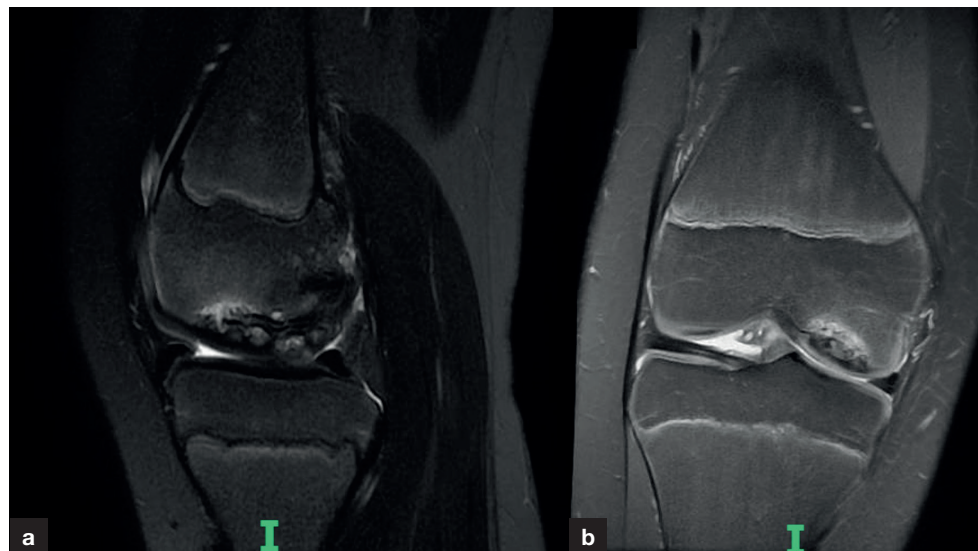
A (a) sagittal and (b) coronal slice T2-weighted magnetic resonance image of the knee demonstrating a medial femoral condyle osteochondral defect.
